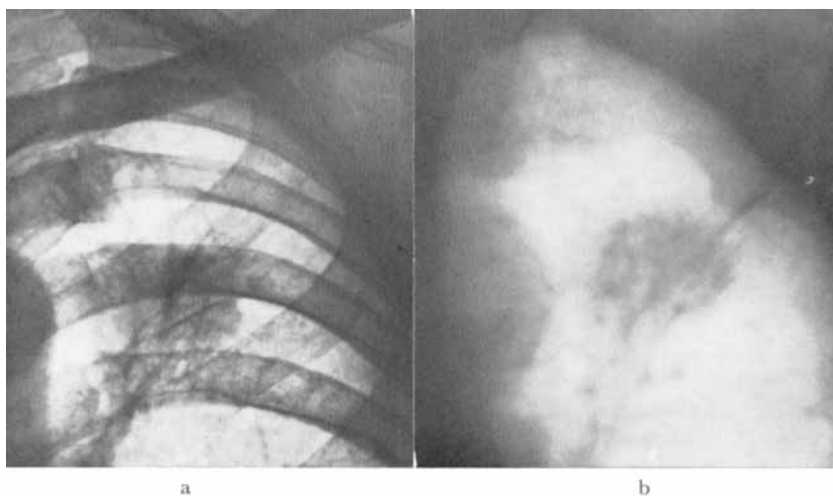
Carcinoma of the lung. a) Diagnostic roentgenogram. b) Beam control film exposed with the linear accelerator for 3 sec. The extent of the tumour is clearly evident in the roentgenogram exposed in the therapy beam.
